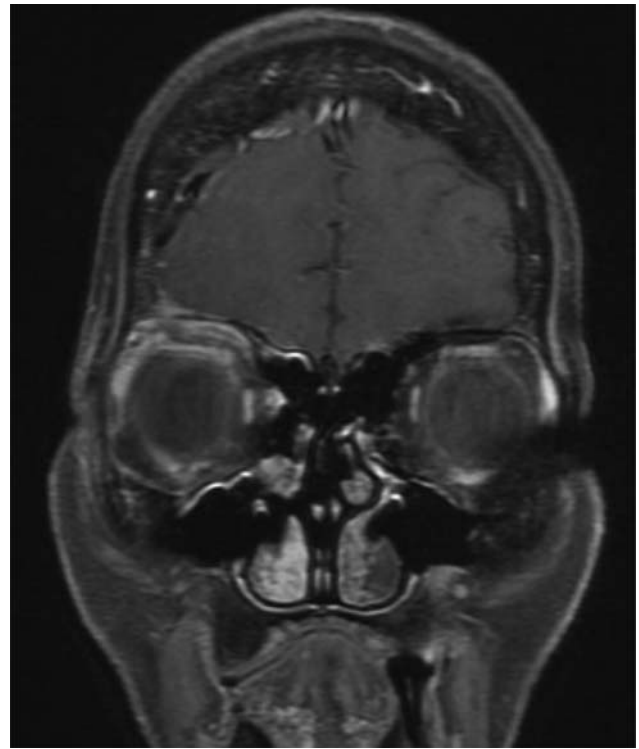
Postoperative coronal, post contrast MRI showing complete resolution of the abscesses in both the orbit and epidural spaces. MRI, magnetic resonance imaging.
